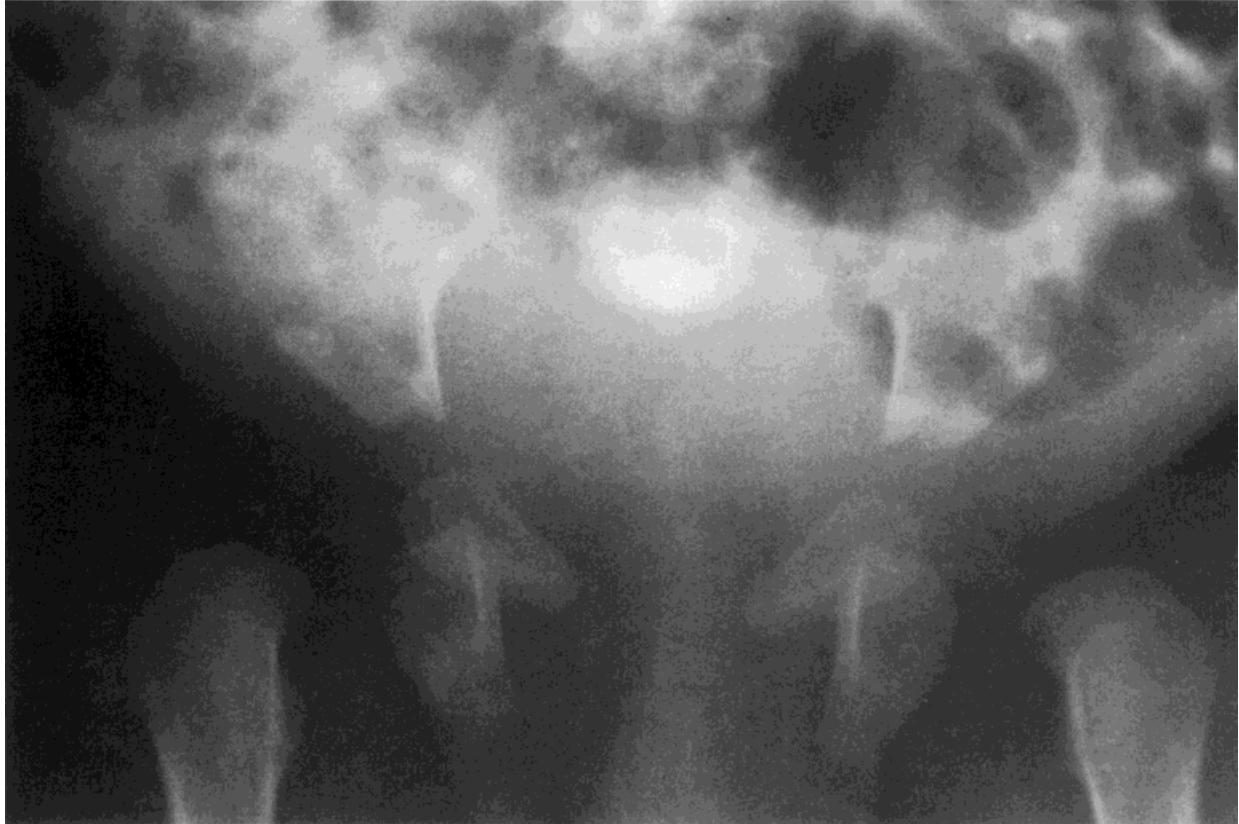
Patient 2, newborn. Radiograph of the pelvis with vertical orientation of the ilia and ischia. The pubis is hypoplastic.
